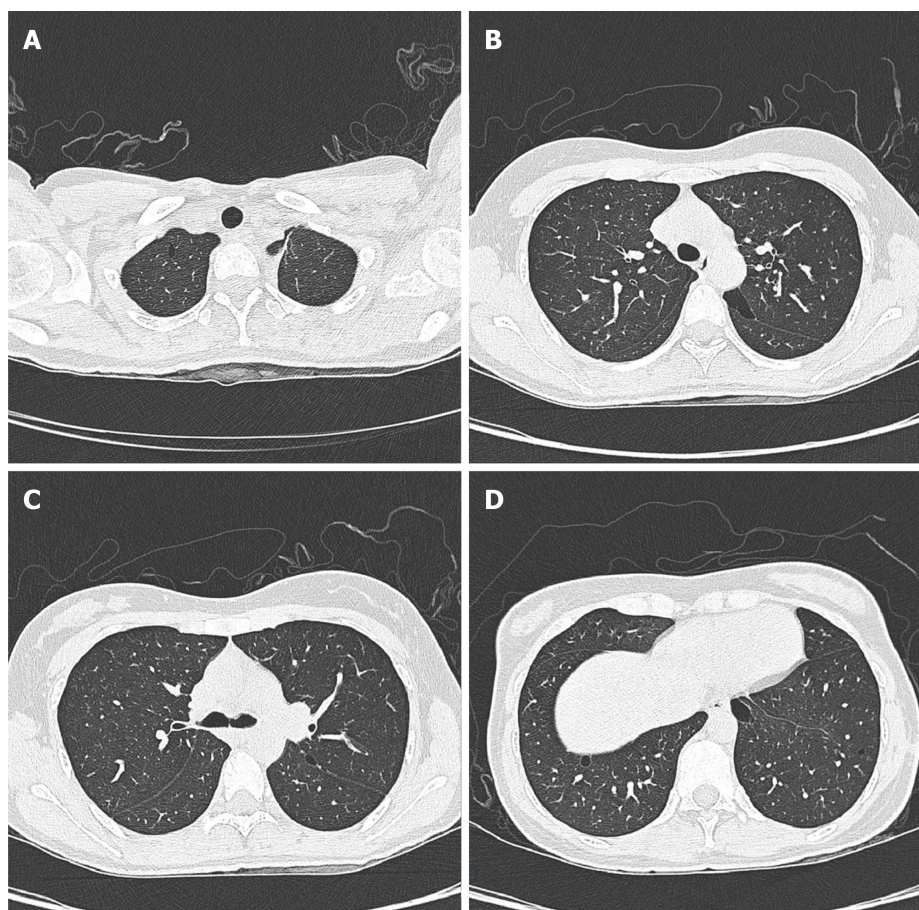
Patient's axial computed tomography image showing multiple thin-walled cysts with clear margins and diverse sizes. A: Small thin-walled cyst located in the apical segment of the right upper lobe; B and C: Irregular morphology cysts located in the apical posterior segment; D: Lower chest showing subpleural cysts at both lung bases.
